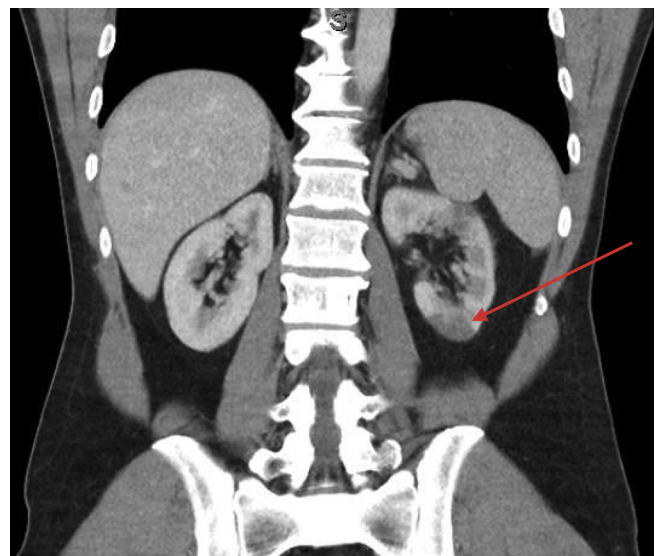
Computed tomography scan of the abdomen with contrast revealed a new area of infarction at the inferior pole of the left kidney (indicated by the arrow).
